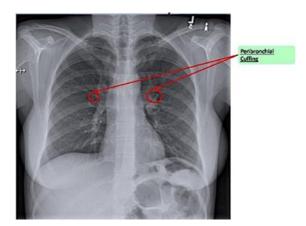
Chest X-ray image of CF, visible peribronchial cuffing.
